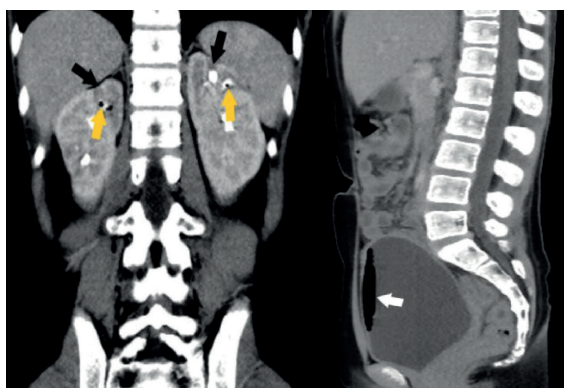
In the coronal contrast-enhanced abdominal computed tomography (CT) image, the size of the right kidney was smaller than the contralateral one. More prominent on the right, there were hypodense areas in both renal cortices, suggesting a scar formation, causing focal recessions (black arrows). There were gas appearances within the bilateral renal calyces (yellow arrows). Leveled gas formation in the bladder lumen seen in the sagittal contrast-enhanced CT image of the abdomen (arrow).
